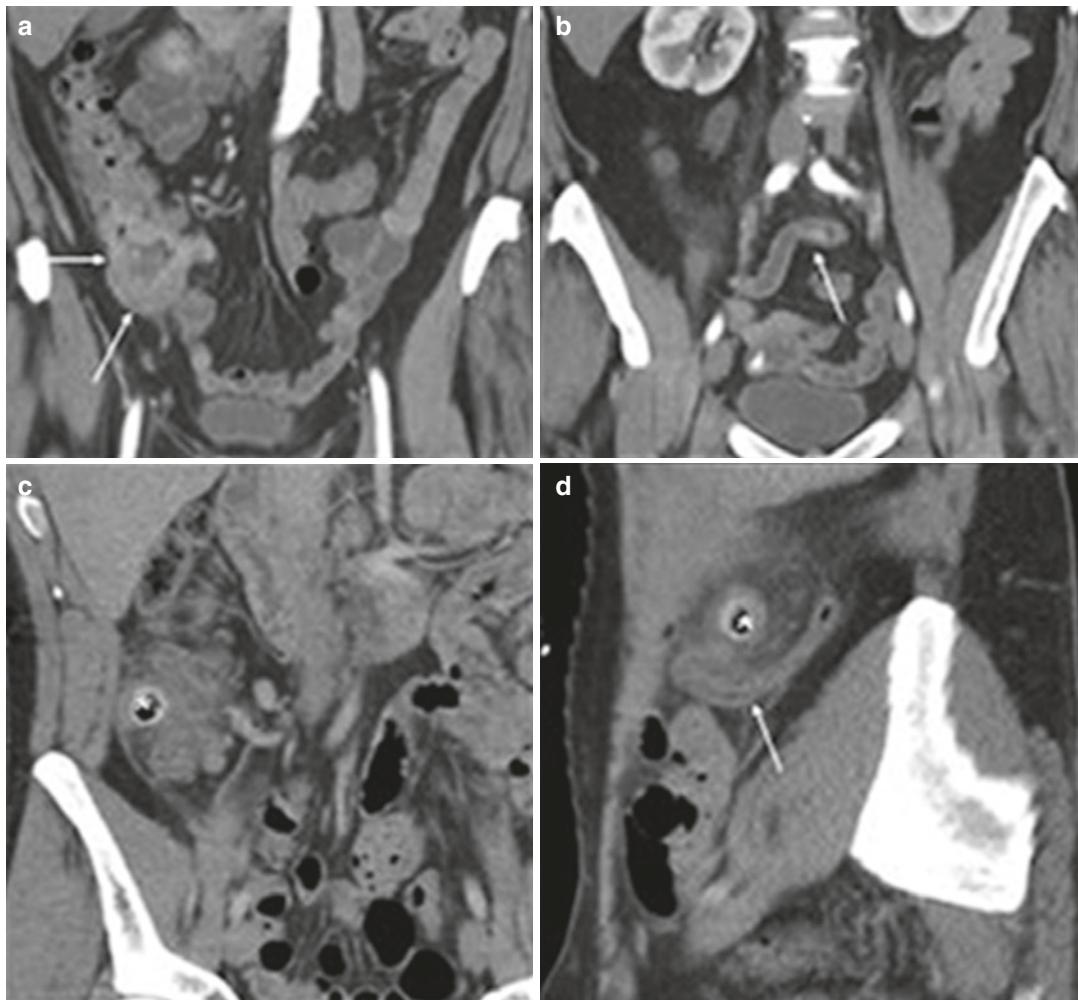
Cecal causes of right lower quadrant pain. Coronal abdominal/pelvic CT images show a soft-tissue mass in the cecum (a, arrows) representing adenocarcinoma with obstruction and dilatation of the appendix in a
